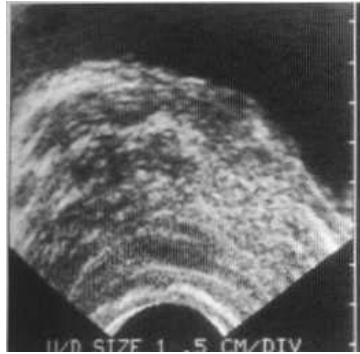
Transrectal ultrasound (transverse image) showing echo-poor tumour infiltrating throughout the prostate, predominantly the right lobe, and extending laterally through the capsule on the right into the periprostatic fat.
